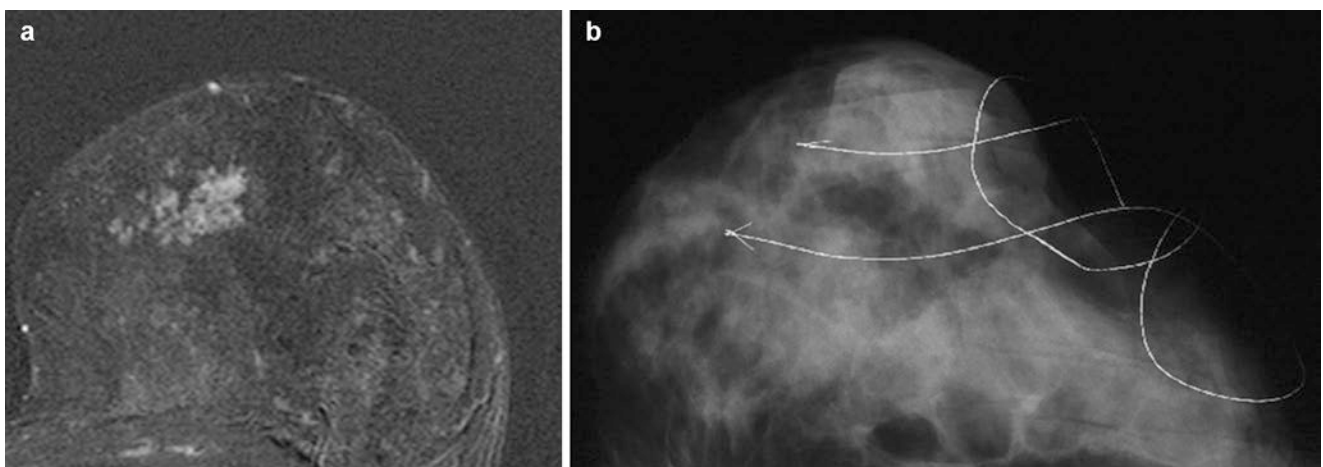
MR-guided surgery. (a) Patient with MRI screening detected non-mass enhancement suggestive of DCIS. MR-guided biopsy (not shown) confirmed presence of high-grade DCIS. Patient underwent MR-guided bracketing of the two poles of the enhancing
